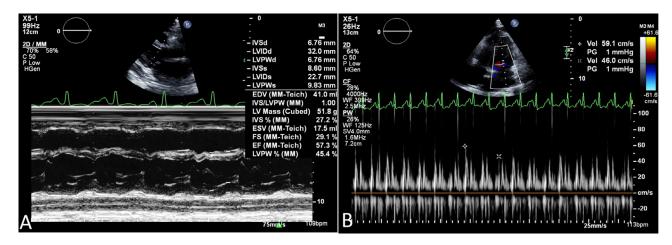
Echocardiogram with paradoxical interventricular septum (A) and respiratory E wave velocity changes (B).
